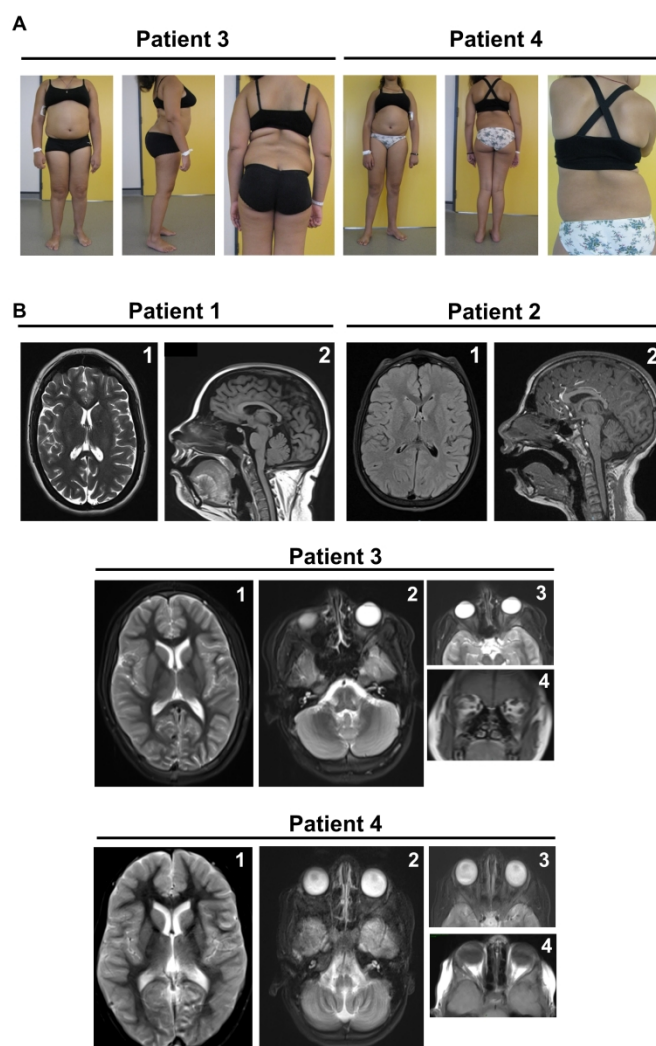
Clinical and brain imaging findings in novel INPP5K-patients. (A) representative photographs of patient 3 and 4 showing severe hyperlordosis. (B) Brain MRI of patients 1-4 showing no brain abnormalities in patients 1, 3 and 4 but a mild cerebellar atrophy in patient 2. Size of oculomotor muscles appears normal in patients 3 & 4 and lenses have obviously been removed with vacuity of the eyes in patient 3 whereas in patient 4 the lenses have not been removed and are well visible within the eye-balls. 1-lateral view; 2-overhead view; 3and 4-ocular view
